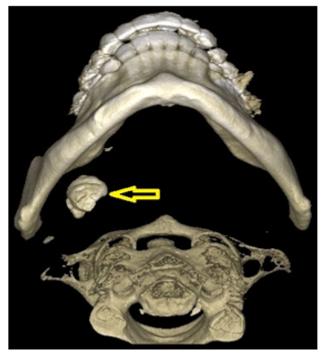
CBCT 3D reconstruction shows the position of the giant right Submandibular Sialolith. (*Photo courtesy:* Buch SA, Babu SG, Hegde S, Rao S, Ajila V. CBCT Imaging of a Giant Sialolith (Megalith). Journal of Dentistry, Oral Disorders & Therapy [Internet]. 2019 Mar 11;7(1)
